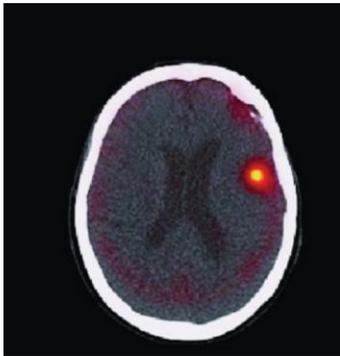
SPECT brain scan with tumor [9]
